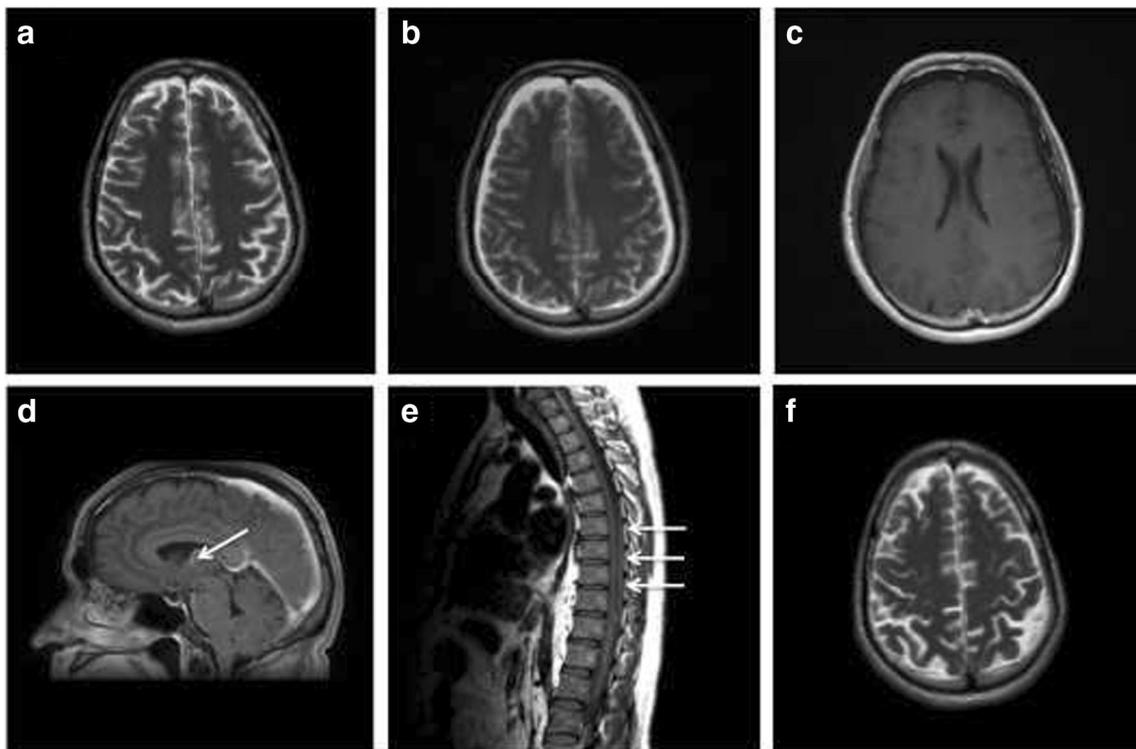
T2 head MRI performed at day 1 (A); T2 (B) and enhanced T1 (C, D) head MRI performed 9 days after admission showing bilateral subdural fluid collections (B), diffuse meningeal enhancement (C), and flattened
